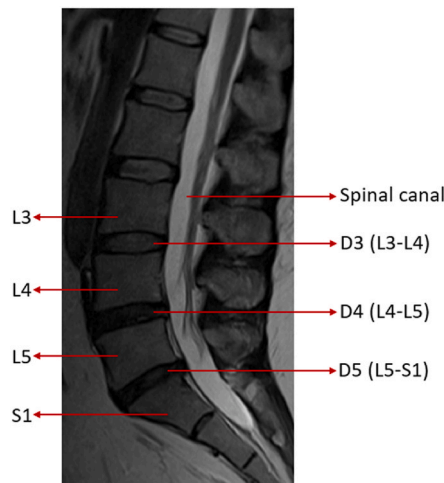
A T2W mid-sagittal view MRI scan of lumbar spine in the dataset.
